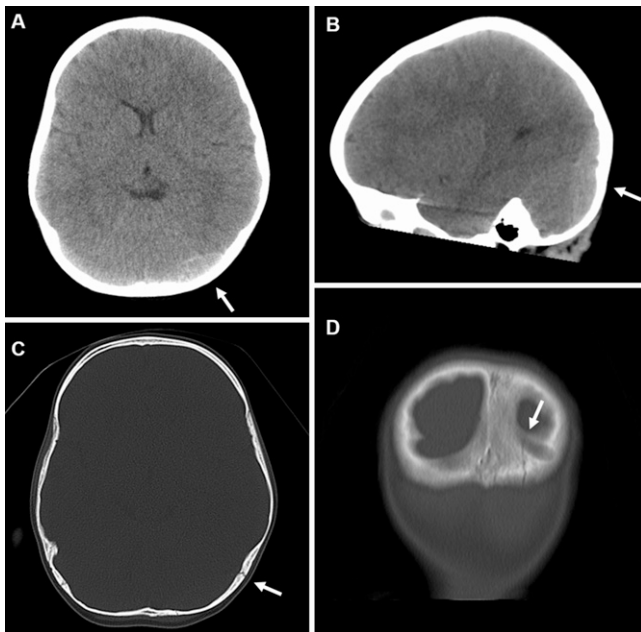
CT scan approximately 1 hour after initial trauma A: Axial CT showing the left occipital PFEDH, reaching the supratentorial space (arrow). Volume ~ 11 cm³. Sagittal (B) and axial (C) images of bone window with parasagittal fracture (arrows). D: Coronal image. Bone window showing the fracture line crossing the sinusoidal groove of the occipital bone (arrow).
